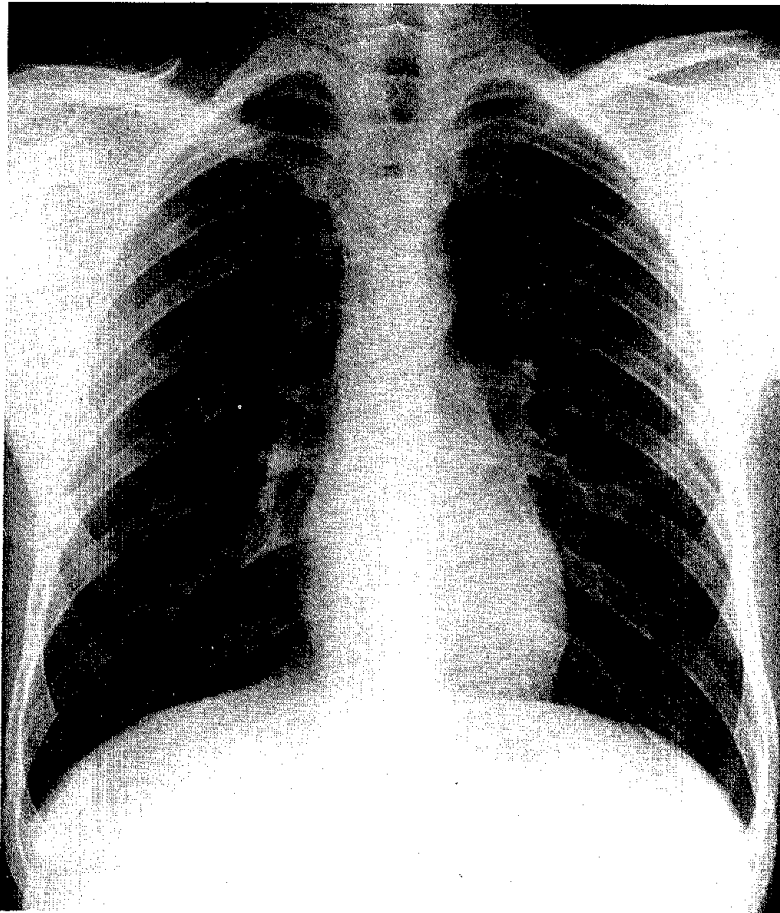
Correct position for a posteroanterior chest radiograph.
